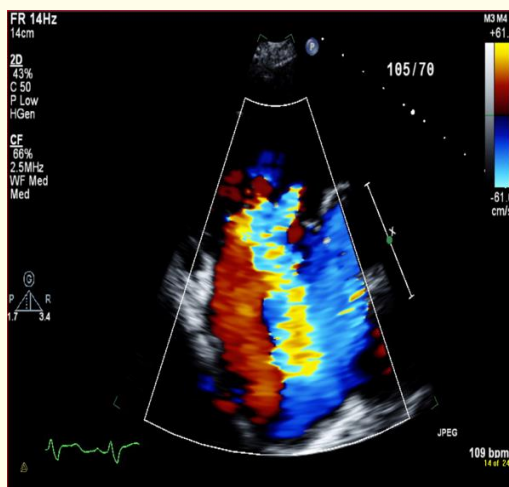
A 2d color doppler over parasternal long axis inflow shows sever right atrial, right ventricle dilatation with sever tricuspid regurgite.
